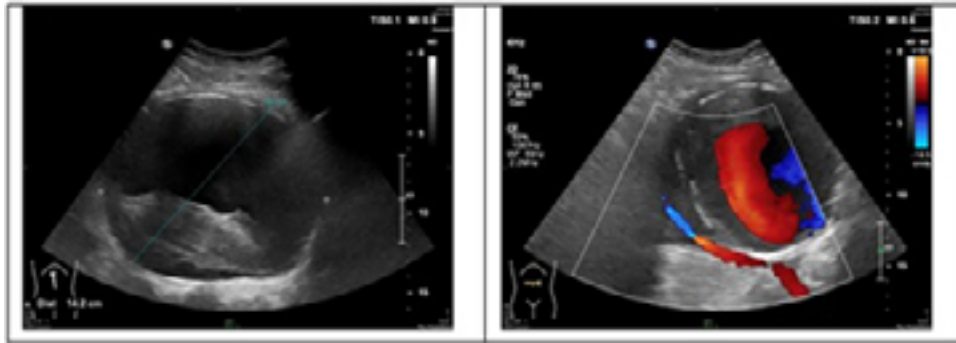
Preoperative ultrasound of the giant infrarenal aortic aneurysm.
